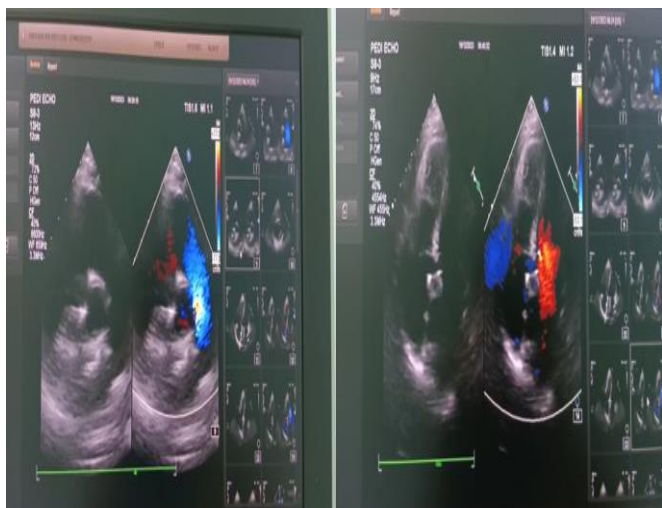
Echocardiography Post ASD Closure
